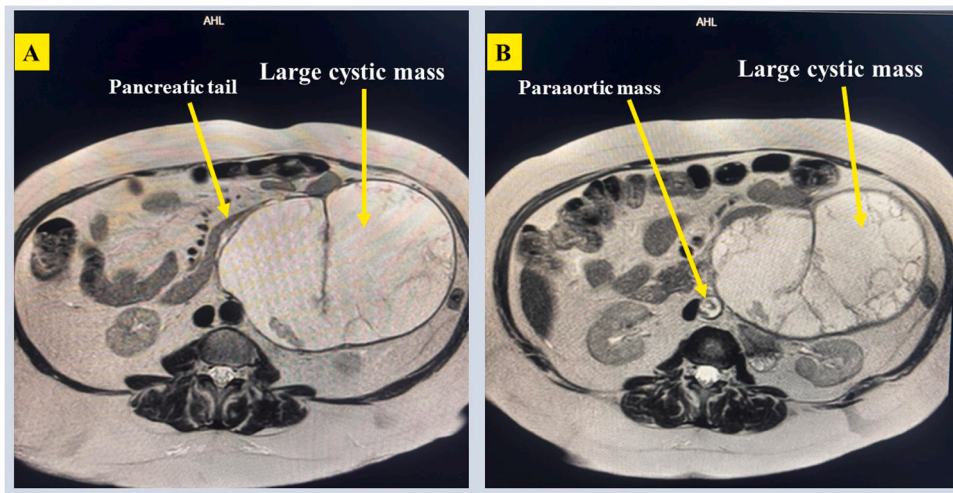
Axial T2 weighted MRI view of the Abdominal Cyst and Para-Aortic Mass.
